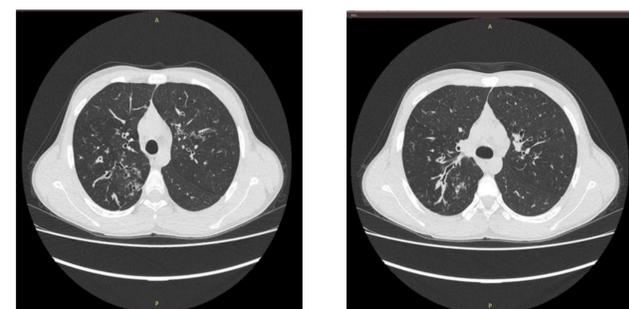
CT scans of patients with allergic bronchopulmonary aspergillosis
